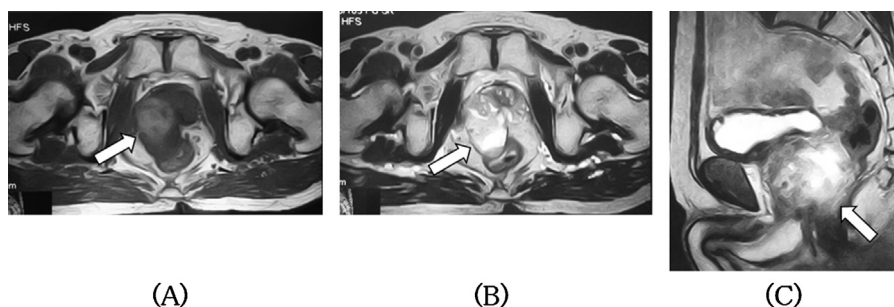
Magnetic resonance imaging. (A) Transverse T1-weighted image showing a homogeneous mass with intermediate signal intensity (arrow). (B) Transverse T2-weighted image showing a heterogeneous mass with high signal intensity (arrow). (C) Sagittal T2-weighted image could not show clear delineation between the tumor and the prostate (arrow).
